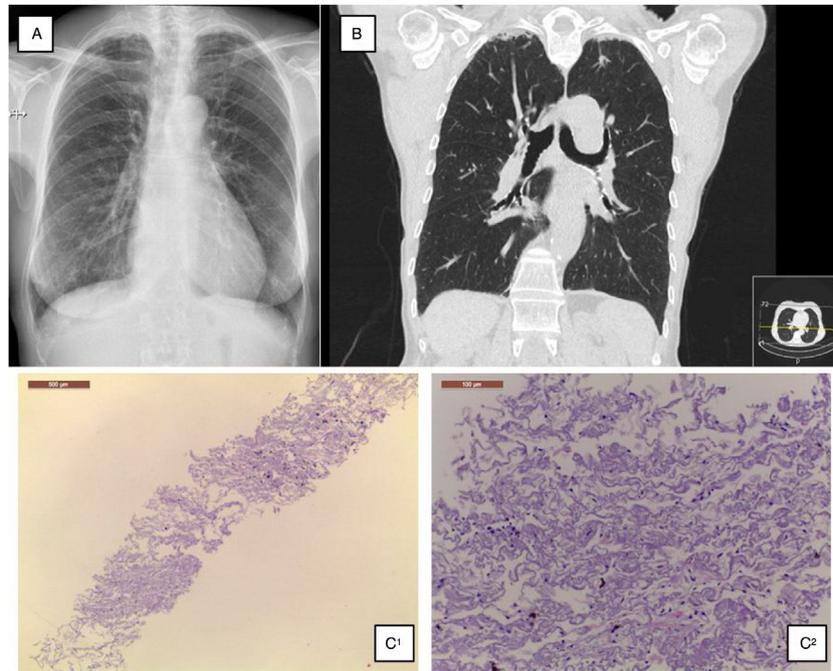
(A) Chest radiograph shows bilateral apical subpleural thickening; (B) coronal CT imaging shows subpleural thickening and reticular opacities with traction bronchiectasis in the parenchyma at the upper lobes, more predominant in the right side; (C) 1 – low magnification showing fibroelastotic scarring; 2 – at high magnification the typical mixture of fragmented elastic fibres and collagen.
